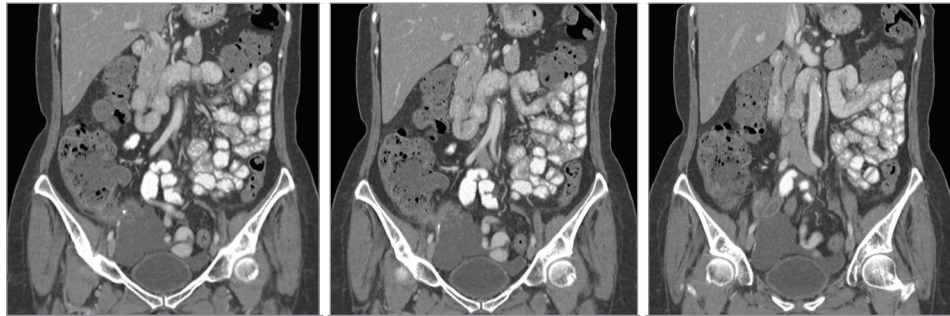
Computed tomography imaging on presentation.
